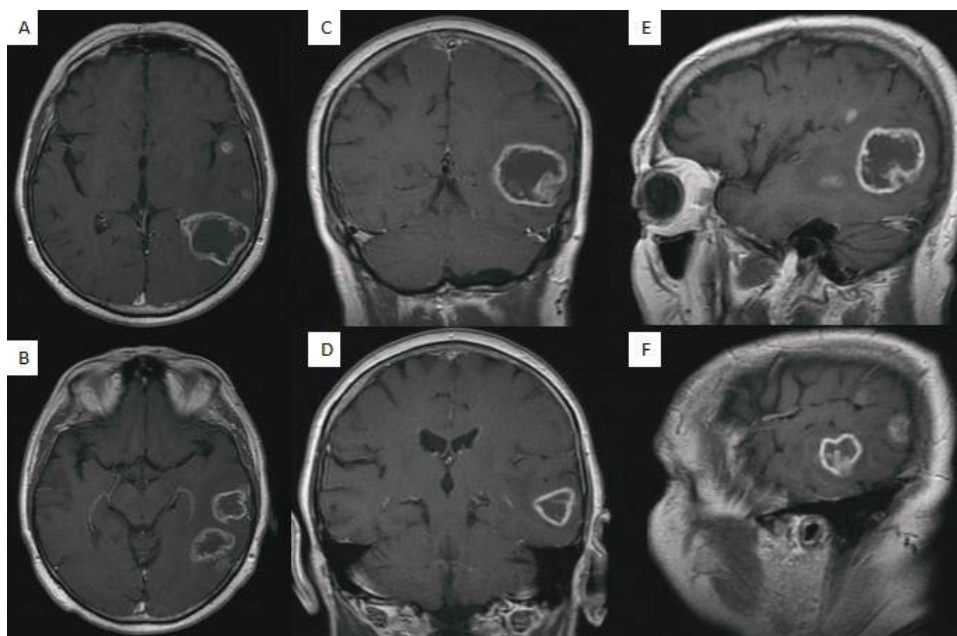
Contrast-enhanced brain MRI.
